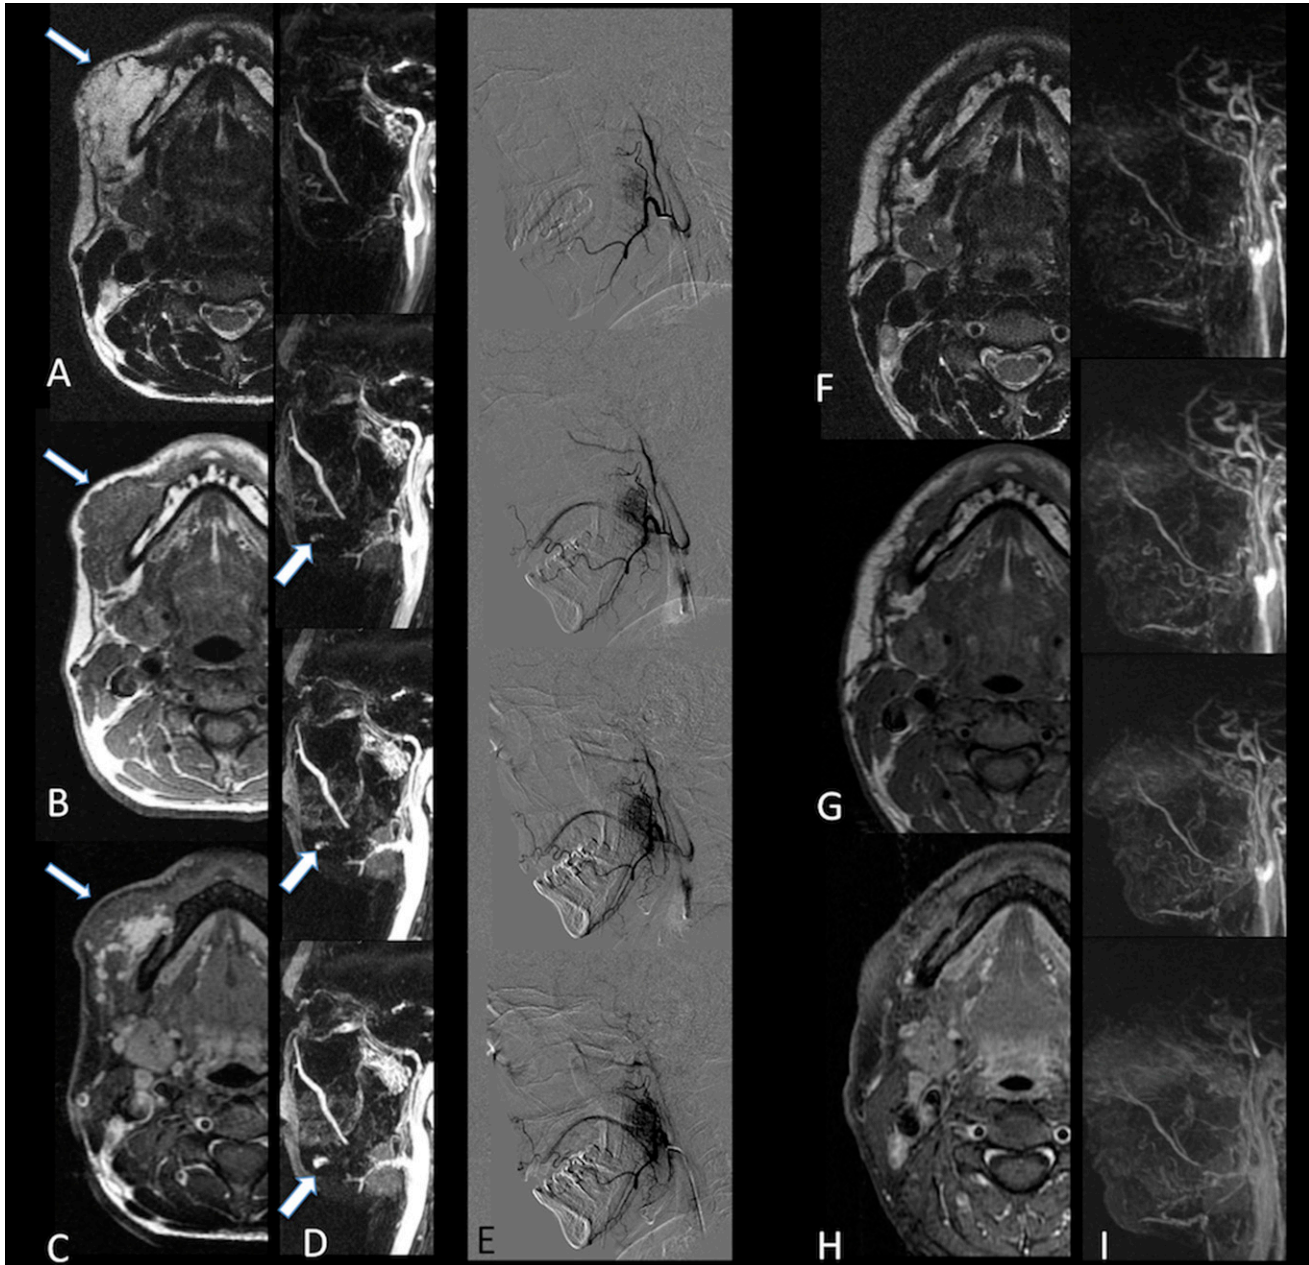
A 44-year-old female (Patient 4) with a right cheek swelling that grew slowly. MRI examination reveals a mass that involves right platysma, close to the jaw border (a–c, thin arrows). After gadolinium, the mass lesion shows enhancement only in its deepest portion (c, thin arrow). Time-resolved imaging of contrast kinetics documents a little area of late enhancement after contrast medium injection inside the lesion (d, thick arrows), absent in early phase of digital subtraction radiography (e). After sclerotherapy, a subtotal regression of lesion is appreciable (f–i).
